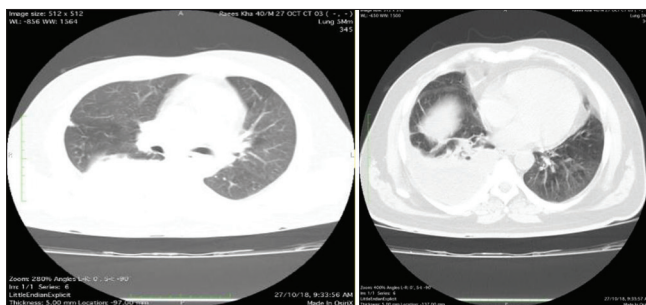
HRCT chest axial sections in a patient with drug-sensitive tuberculosis showing right-sided pleural effusion with areas of ground-glass haziness.
